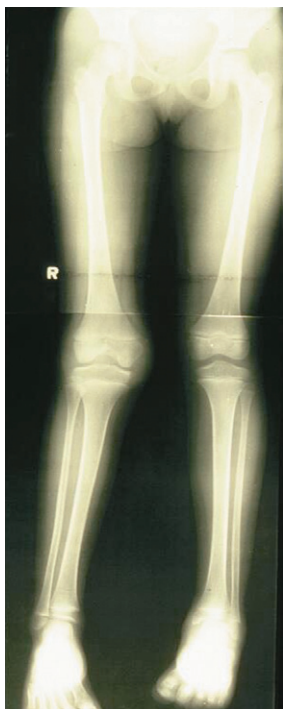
Radiograph of a young girl with oligoarticular juvenile idiopathic arthritis involving the right knee, demonstrating bony hypertrophy of the affected knee, with leg-length discrepancy and flexion contracture.
